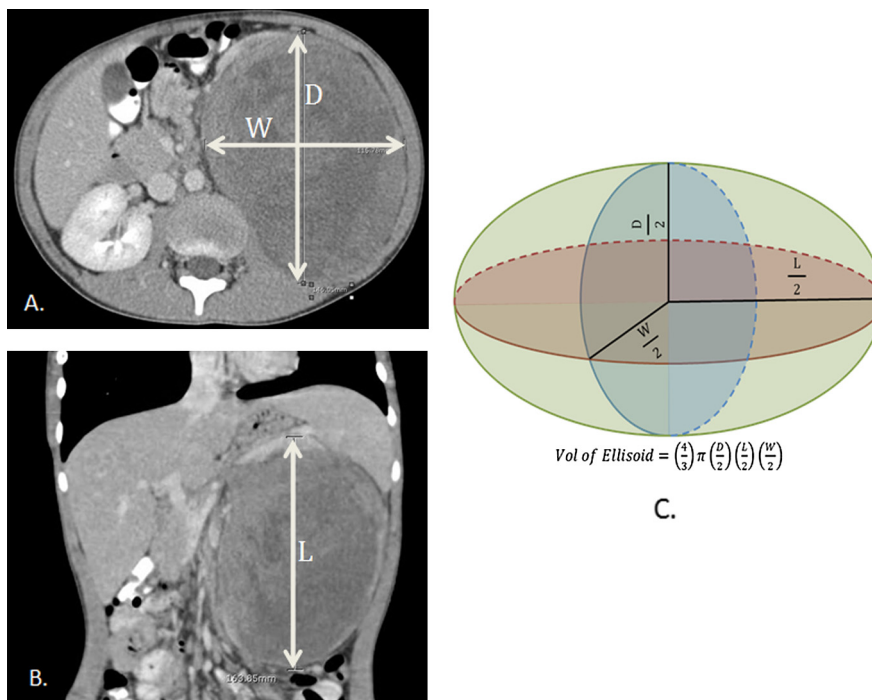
A. Example estimating depth (D) and width (W) in axial view of computed tomography (CT) scan. B. Example estimating length (L) in sagittal view of CT scan. C. Formula used to estimate tumor volume.
